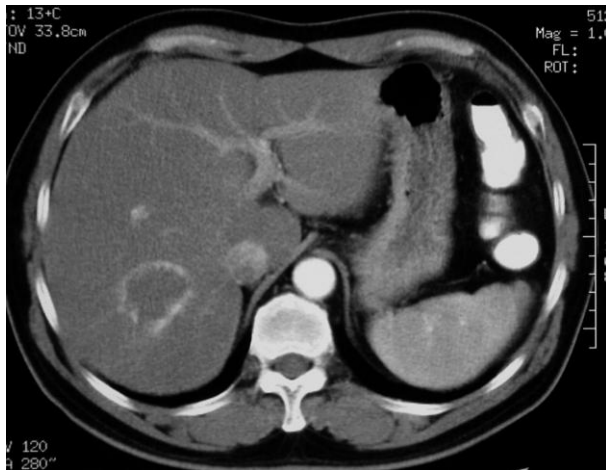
Hepatic hemangioma. Arterial phase CT image shows a peripheral enhancement of a tumor mass at posterior segment of right hepatic lobe. Note that the aorta is marked enhanced.
